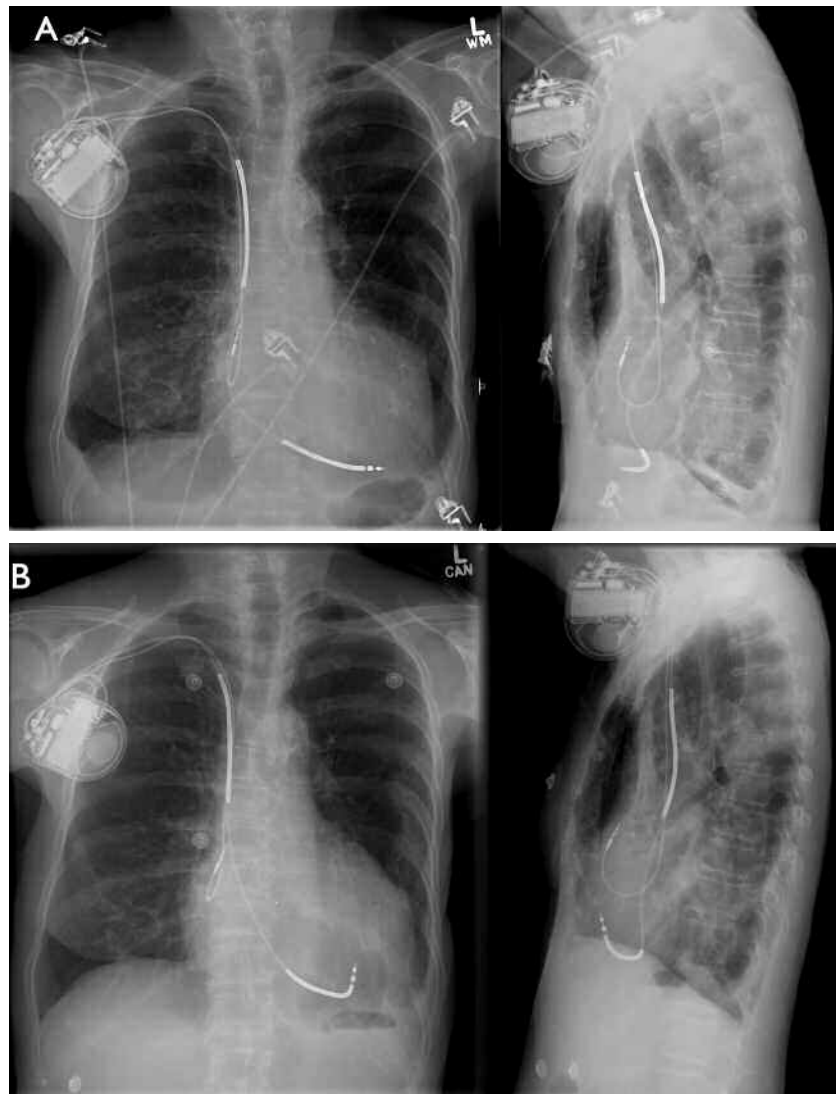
Chest radiograph demonstrating ventricular lead position at time of device implantation (A) and post-migration at time of presentation with tamponade (B).
